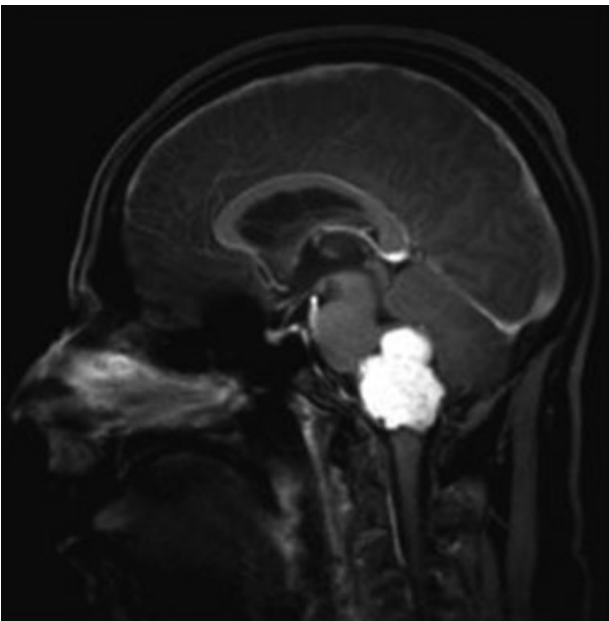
Encephalon T1-weighted MRI scan with contrast demonstrating tumor mass in the region of the fourth ventricle, with homogeneous enhancement and an important mass effect on the brainstem in the sagittal section.
